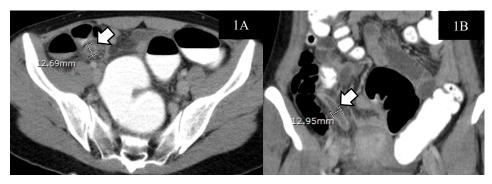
Axial (A) and coronal (B) contrast-enhanced CT images of acute appendicitis show dilated non-opacified appendix (>6mm) (arrow).
